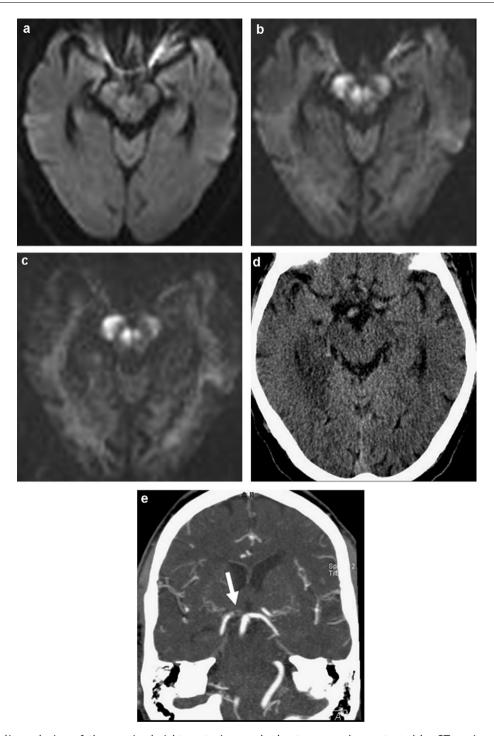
Embolic occlusion of the proximal right posterior cerebral artery was demonstrated by CT angiography (e, arrow). Hyperacute ischemic lesion in the right mesencephalon. Delay from stroke onset was 165 minutes. Lesion conspicuity was higher, and lesion extent was bigger on b = 5000 (c) and b = 3000 images (b) compared to b = 1000 images (a). On follow-up CT (d) 1 day later, hypodense infarction in the right mesencephalon and temporal lobe is shown.
